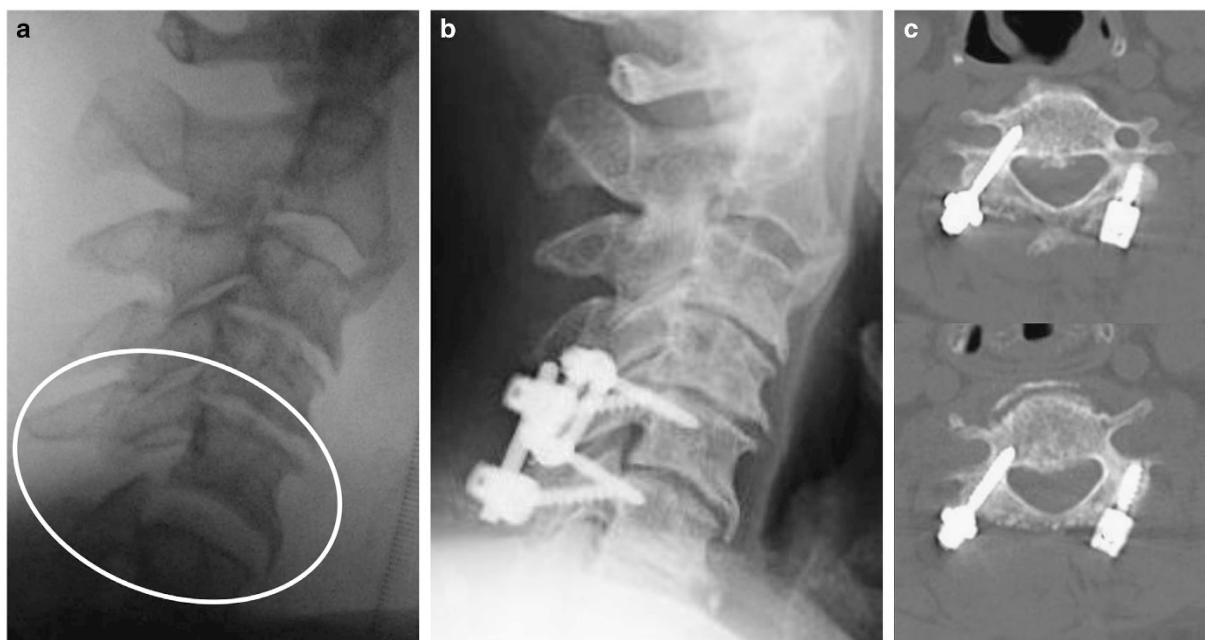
Intraoperative X-ray imaging (a) and postoperative X-ray and CT scans (b,c). Stability of all around vertebral tissues was disrupted, and the interval of C5/6 was easily spread with traction force under anesthesia (a). Posterior fusion with reduced alignment (b).
